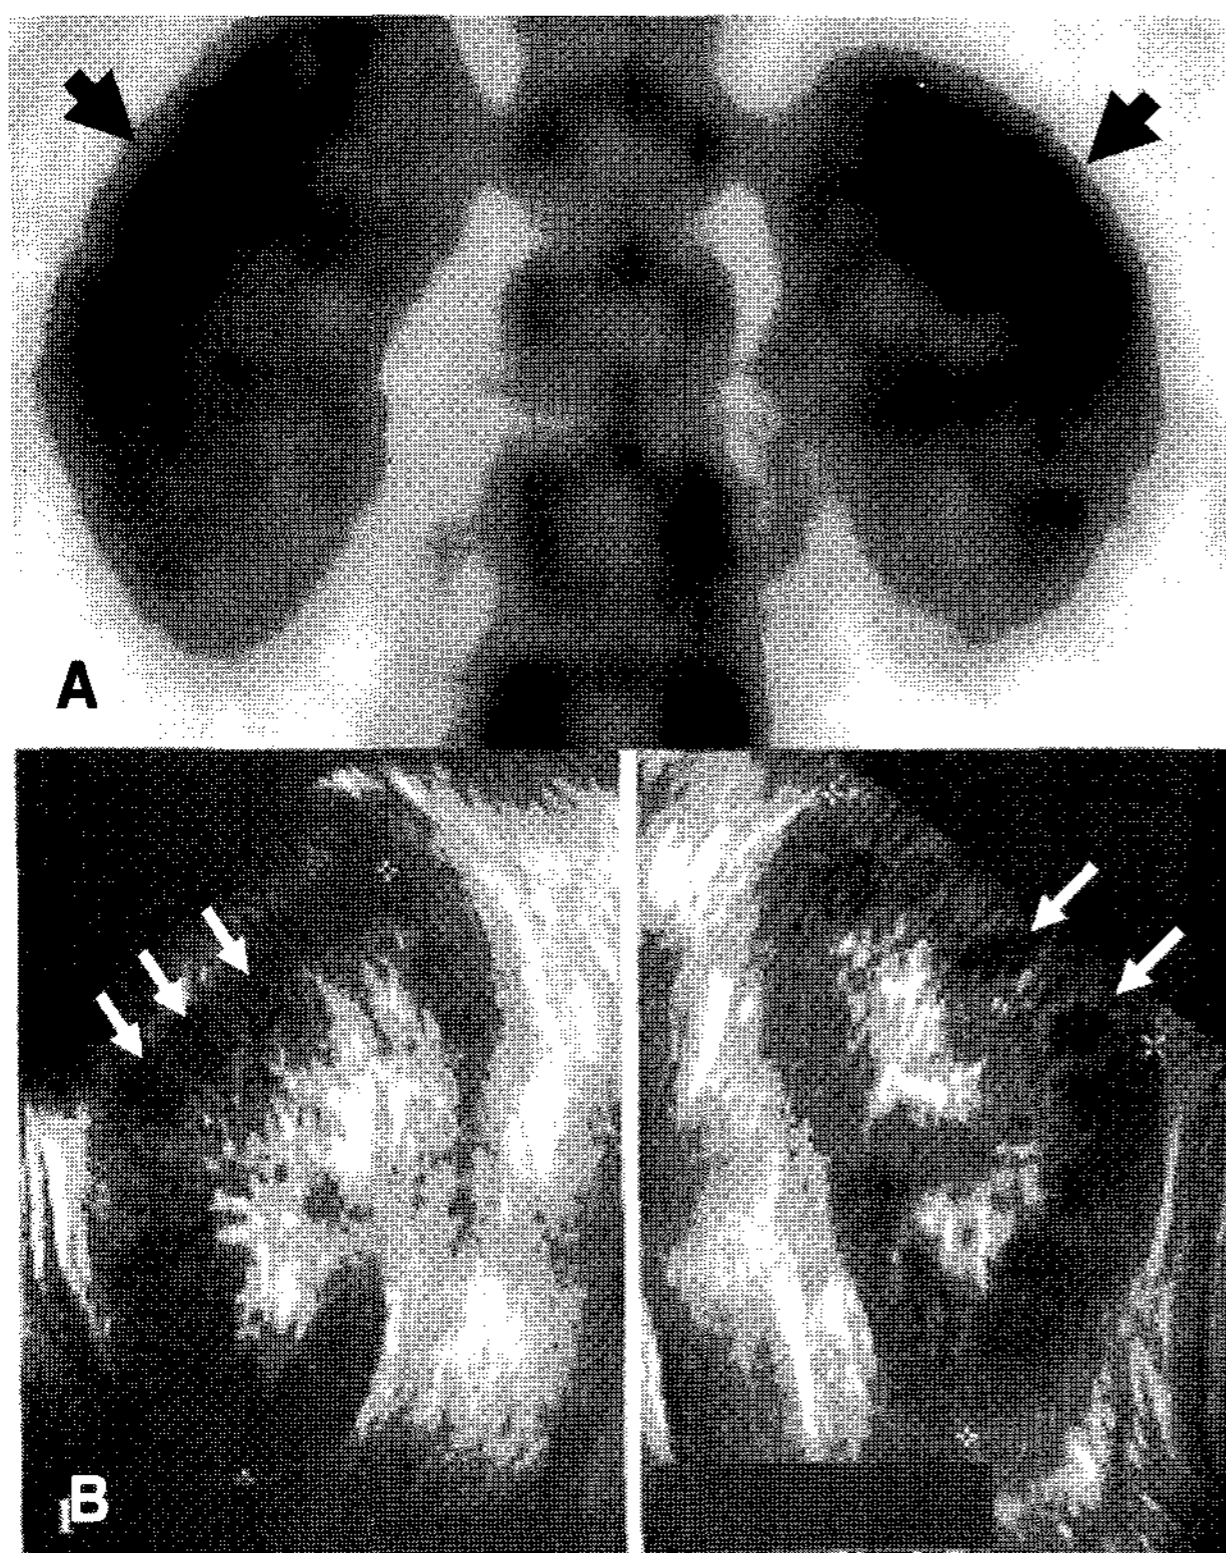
(A) Close-up renal scan shows increased tracer uptake in parenchyma of both kidneys (black arrows). (B) Sonography shows diffusely increased parenchymal echo, well-defined swollen pyramids (white arrows) and mild global enlargement. Note that increased echo well matches with increased tracer uptake.
